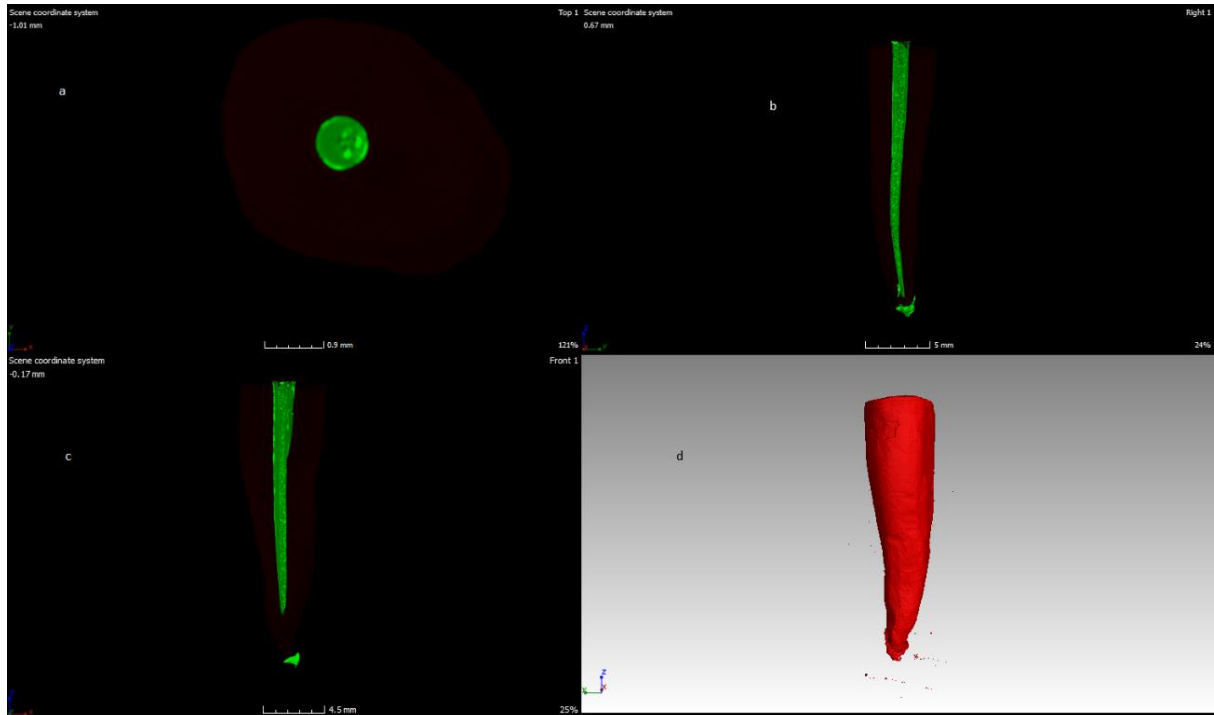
2-D view from the μ CT scan.
